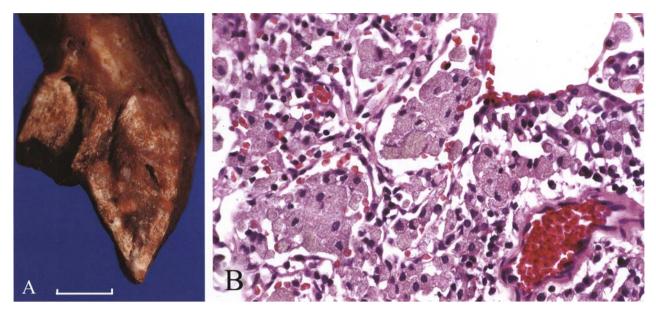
Barium sulfate aspiration. A. Tan-white parenchymal discoloration due to peripheral deposition of aspirated barium radiographic contrast material in this pediatric lung
